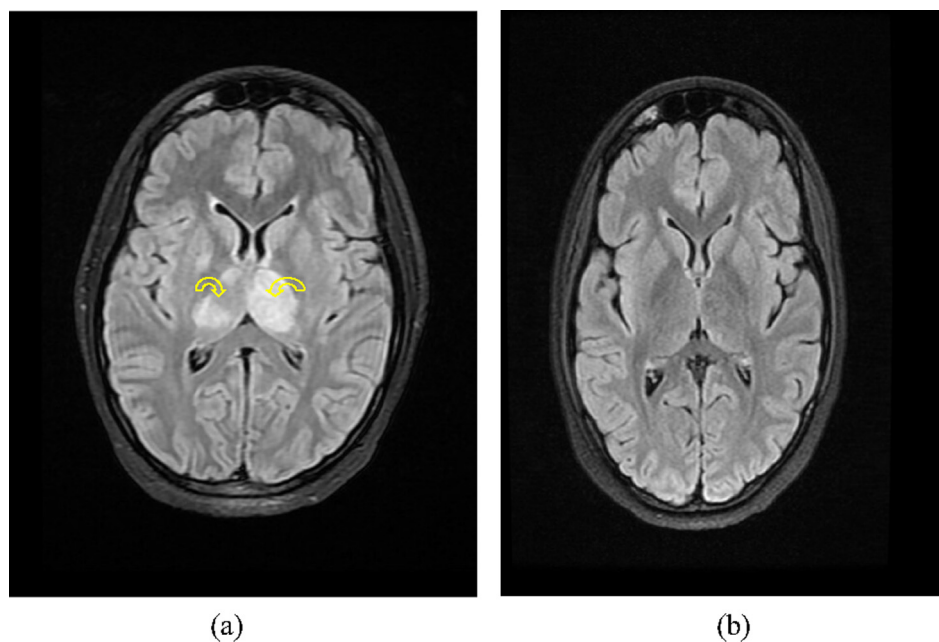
(a): Magnetic resonance imaging of brain prior to plasmapheresis showing hyperintense signal in bilateral thalami (pointed arrows). (b) Resolution of ADEM after six sessions of plasmapheresis.
